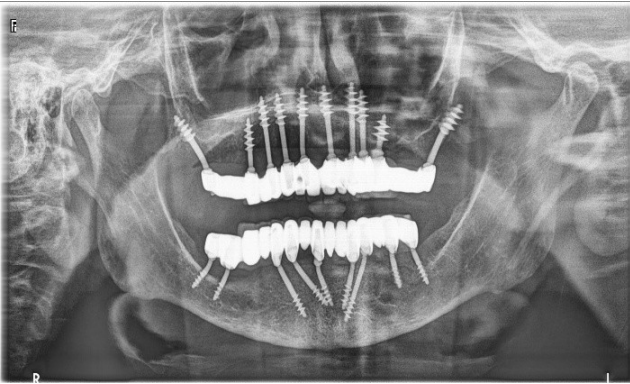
Panoramic radiograph showing full-mouth implant-supported fixed prostheses porcelain fused to metal in both the maxilla and mandible with multiple osseointegrated dental implants.
